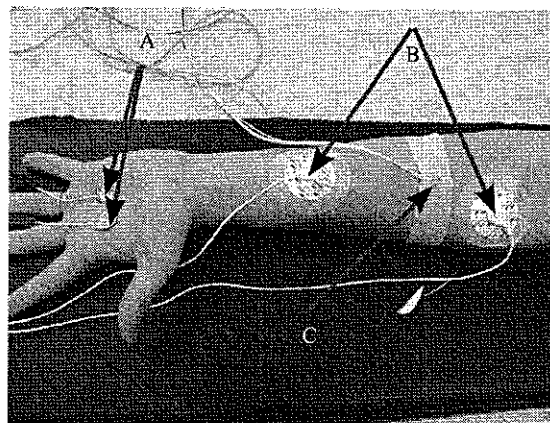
Experimental setup: (a) SEI electrodes connected with the CED Model 2502 Skin Conductance unit. (b) Stimulating electrodes (3M Red Dot) driven by FREMS, Aptiva 1.5 Lorenz Biotech S.P.A. (c) Laser Doppler probe Perimed PROBE 457.
